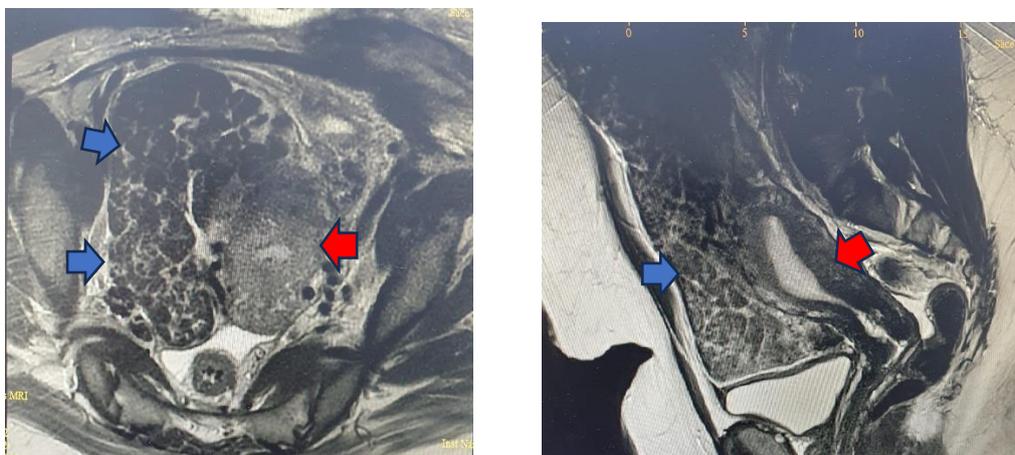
Magnetic resonance images (MRI) of abdomen using gadolinium-based contrast media. Left: Axial view. Right: Sagittal view. (Red arrow: uterus; Blue arrow: leiomyomatosis peritonealis disseminata.)
